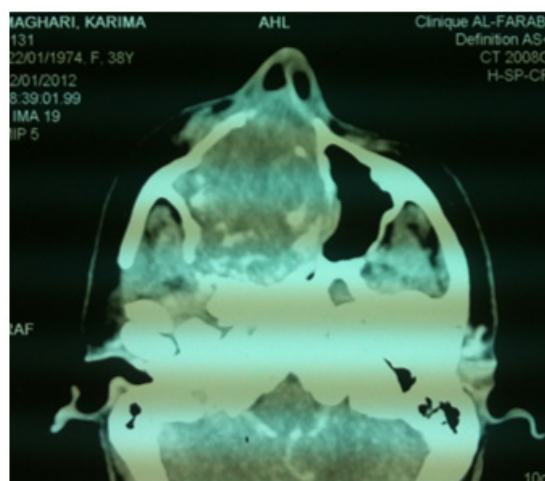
Axial CT-scan: voluminous maxillary lesion with intra tumoral Calcification.
